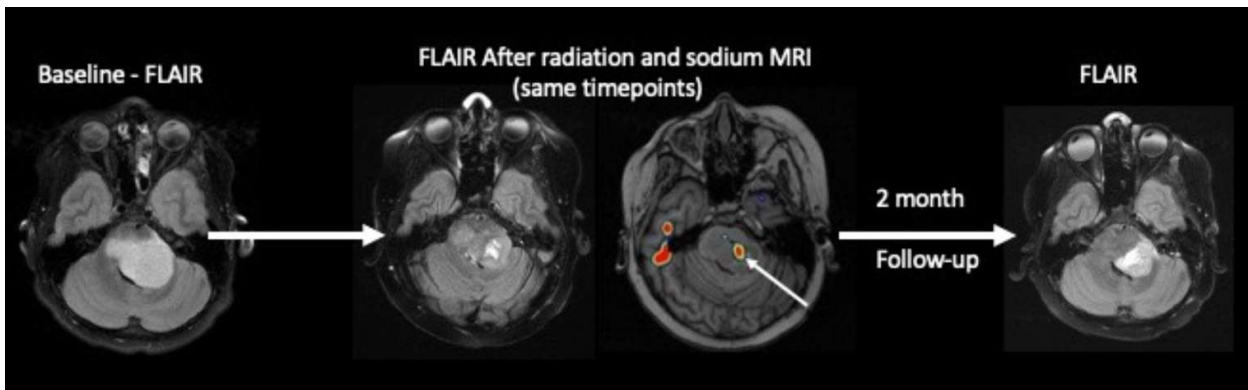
Pediatric DMG patient from above. The increased focus of sodium concentrations (arrow) in the tumor was acquired after radiation treatment; this region may represent: a) radioresistant region of the tumor b) region of tumor progression. Follow-up conventional MRI a further two months after radiation cessation demonstrates tumor progression in the region of the prior sodium elevation. *This anecdote supports the hypothesis that elevated sodium signal represents an early biomarker of tumor progression/recurrence.*
